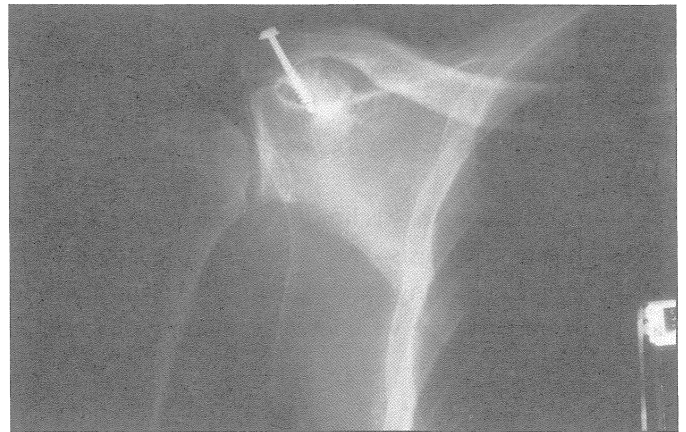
Post-operative radiograph of Botsworth procedure
